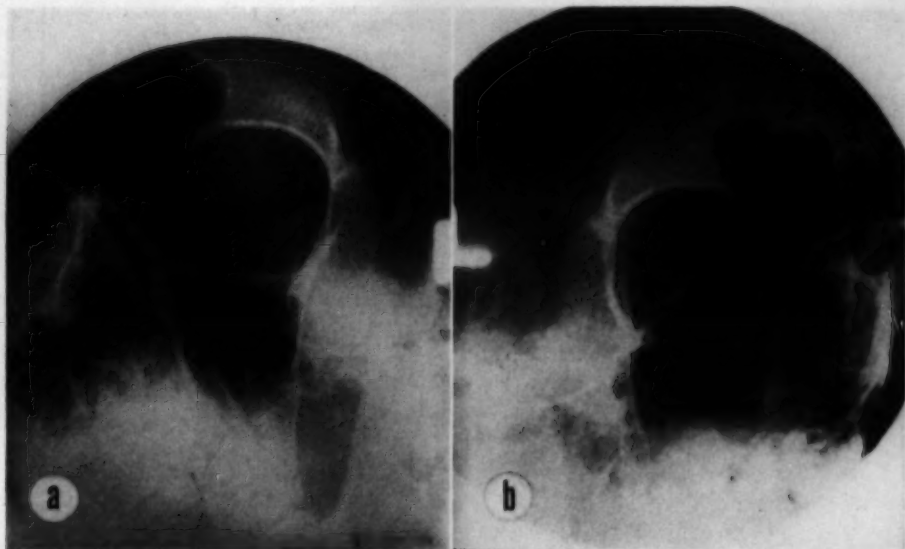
(Goodman). X-ray films of the orbits (January 16, 1951). There is definite clouding of the right (a) orbital cavity as compared with the left (b). The right optic foramen shows a loss of integrity of the wall at the superolateral margin.
